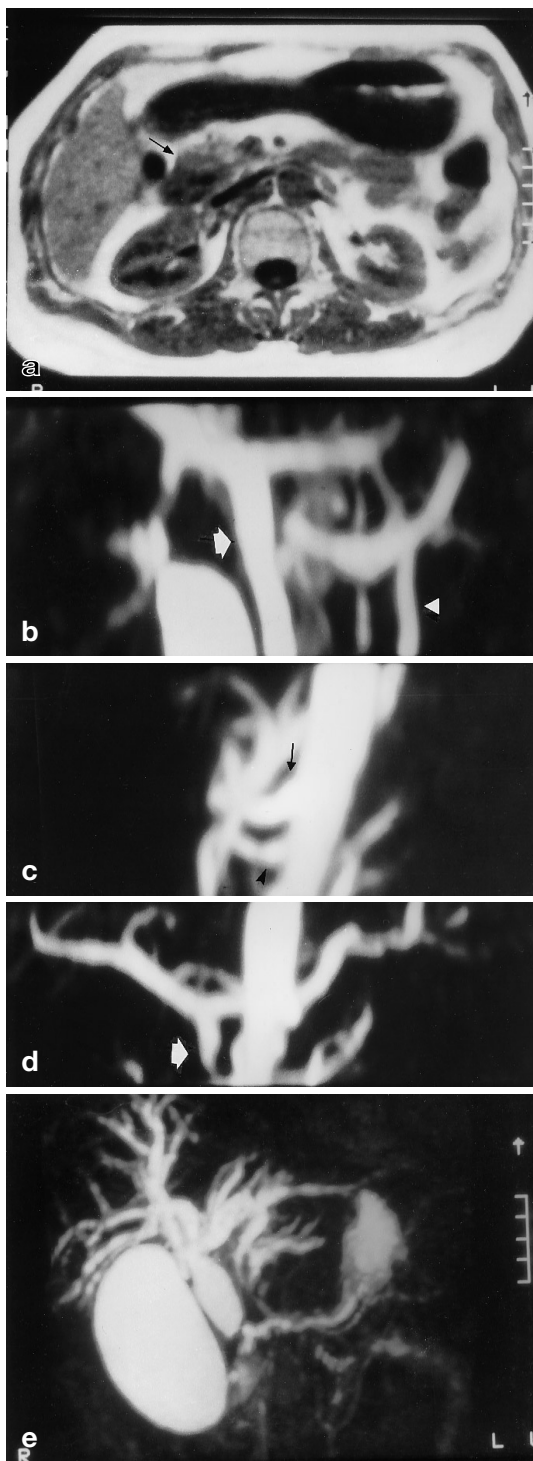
a–e. Pancreatic head carcinoma. a T1-weighted SE image shows a hypointense mass (*arrow*) adjacent to the duodenum. b MRA demonstrates patency of the SMV (*arrow*), splenic vein, and portal vein, with good evaluation also of the inferior mesenteric vein (*arrowhead*). c The arterial phase shows, on a lateral projection, the origin of the celiac trunk (*arrow*) and SMA (*arrowhead*), which both result patent. d A coronal projection allows depiction of the progressive reduction in caliber of the gastroduodenal artery, encased by the tumor (*arrow*). e MRCP shows a marked dilatation of the biliary and pancreatic ducts, with a double duct sign
